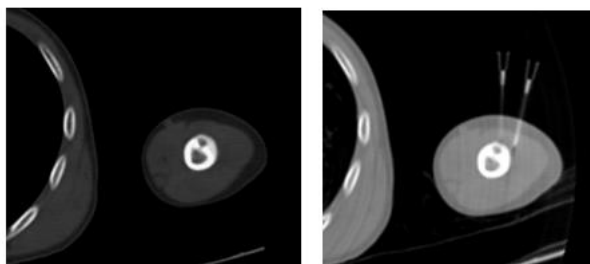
CT guided Localization of the lesion and local anesthesia injection.
